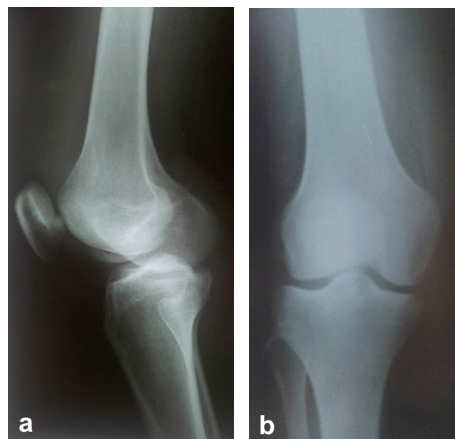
(a) Lateral and (b) anteroposterior X-rays performed before surgery. Visual signs of the chondral damage can be seen on the first X-ray, but they seem to not be visible on the anteroposterior one.
